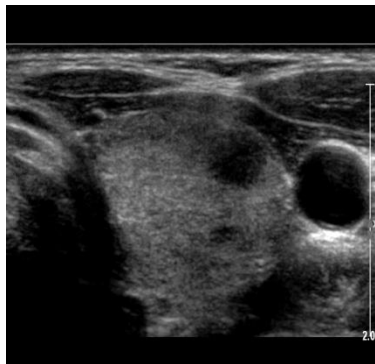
Grey scale Ultrasonography showing markedly hypoechoic nodule with ill-defined irregular margin- TIRADS 4B.
